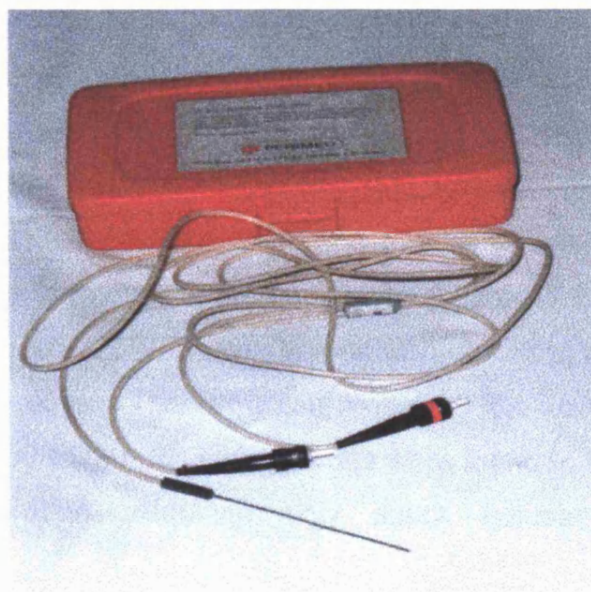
The Laser Doppler probe (Probe 403)
